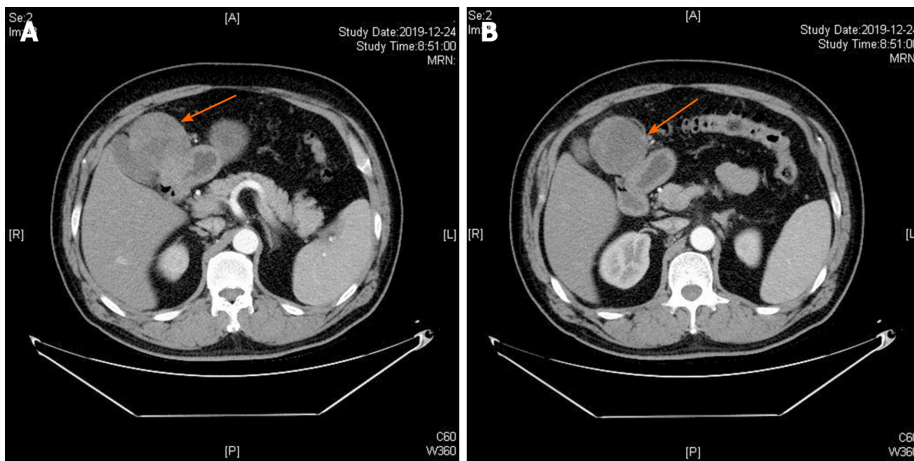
Contrast-enhanced computed tomography axial view revealed a tumor mass with an inhomogeneous enhancement in the arterial phase (A and B).
